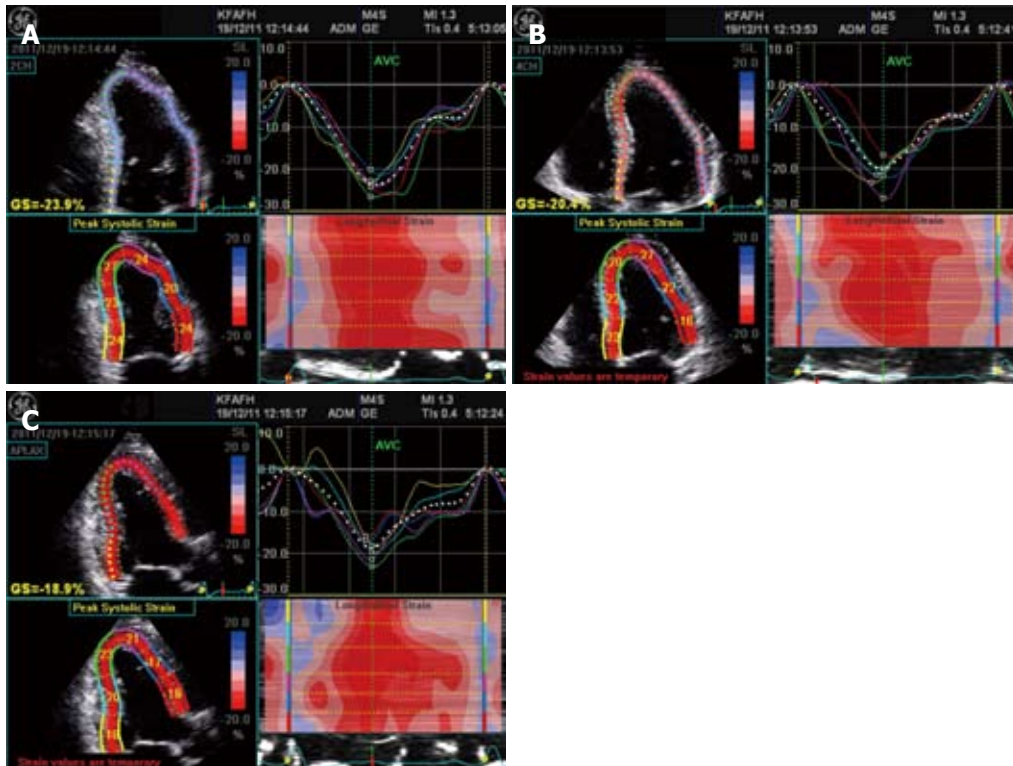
Segmental longitudinal strain displayed in 3 image planes. A: Apical 4-chamber; B: Apical 2-chamber; C: Apical long axis views.
